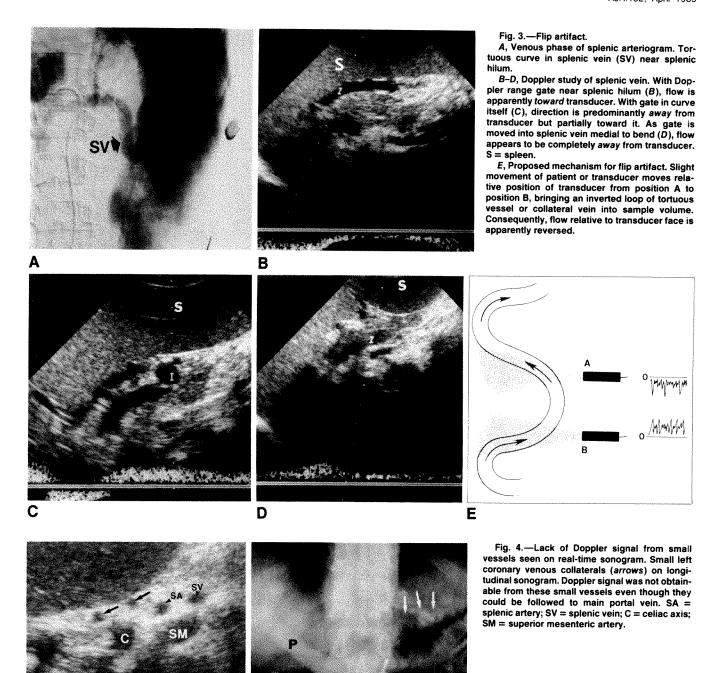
Venous phase of superior mesenteric arterial injection. Faintly opacified varices near proximal lesser curvature aspect of stomach (arrows) were also seen on endoscopy but were invisible on both real-time and Doppler sonography. P = portal vein.
